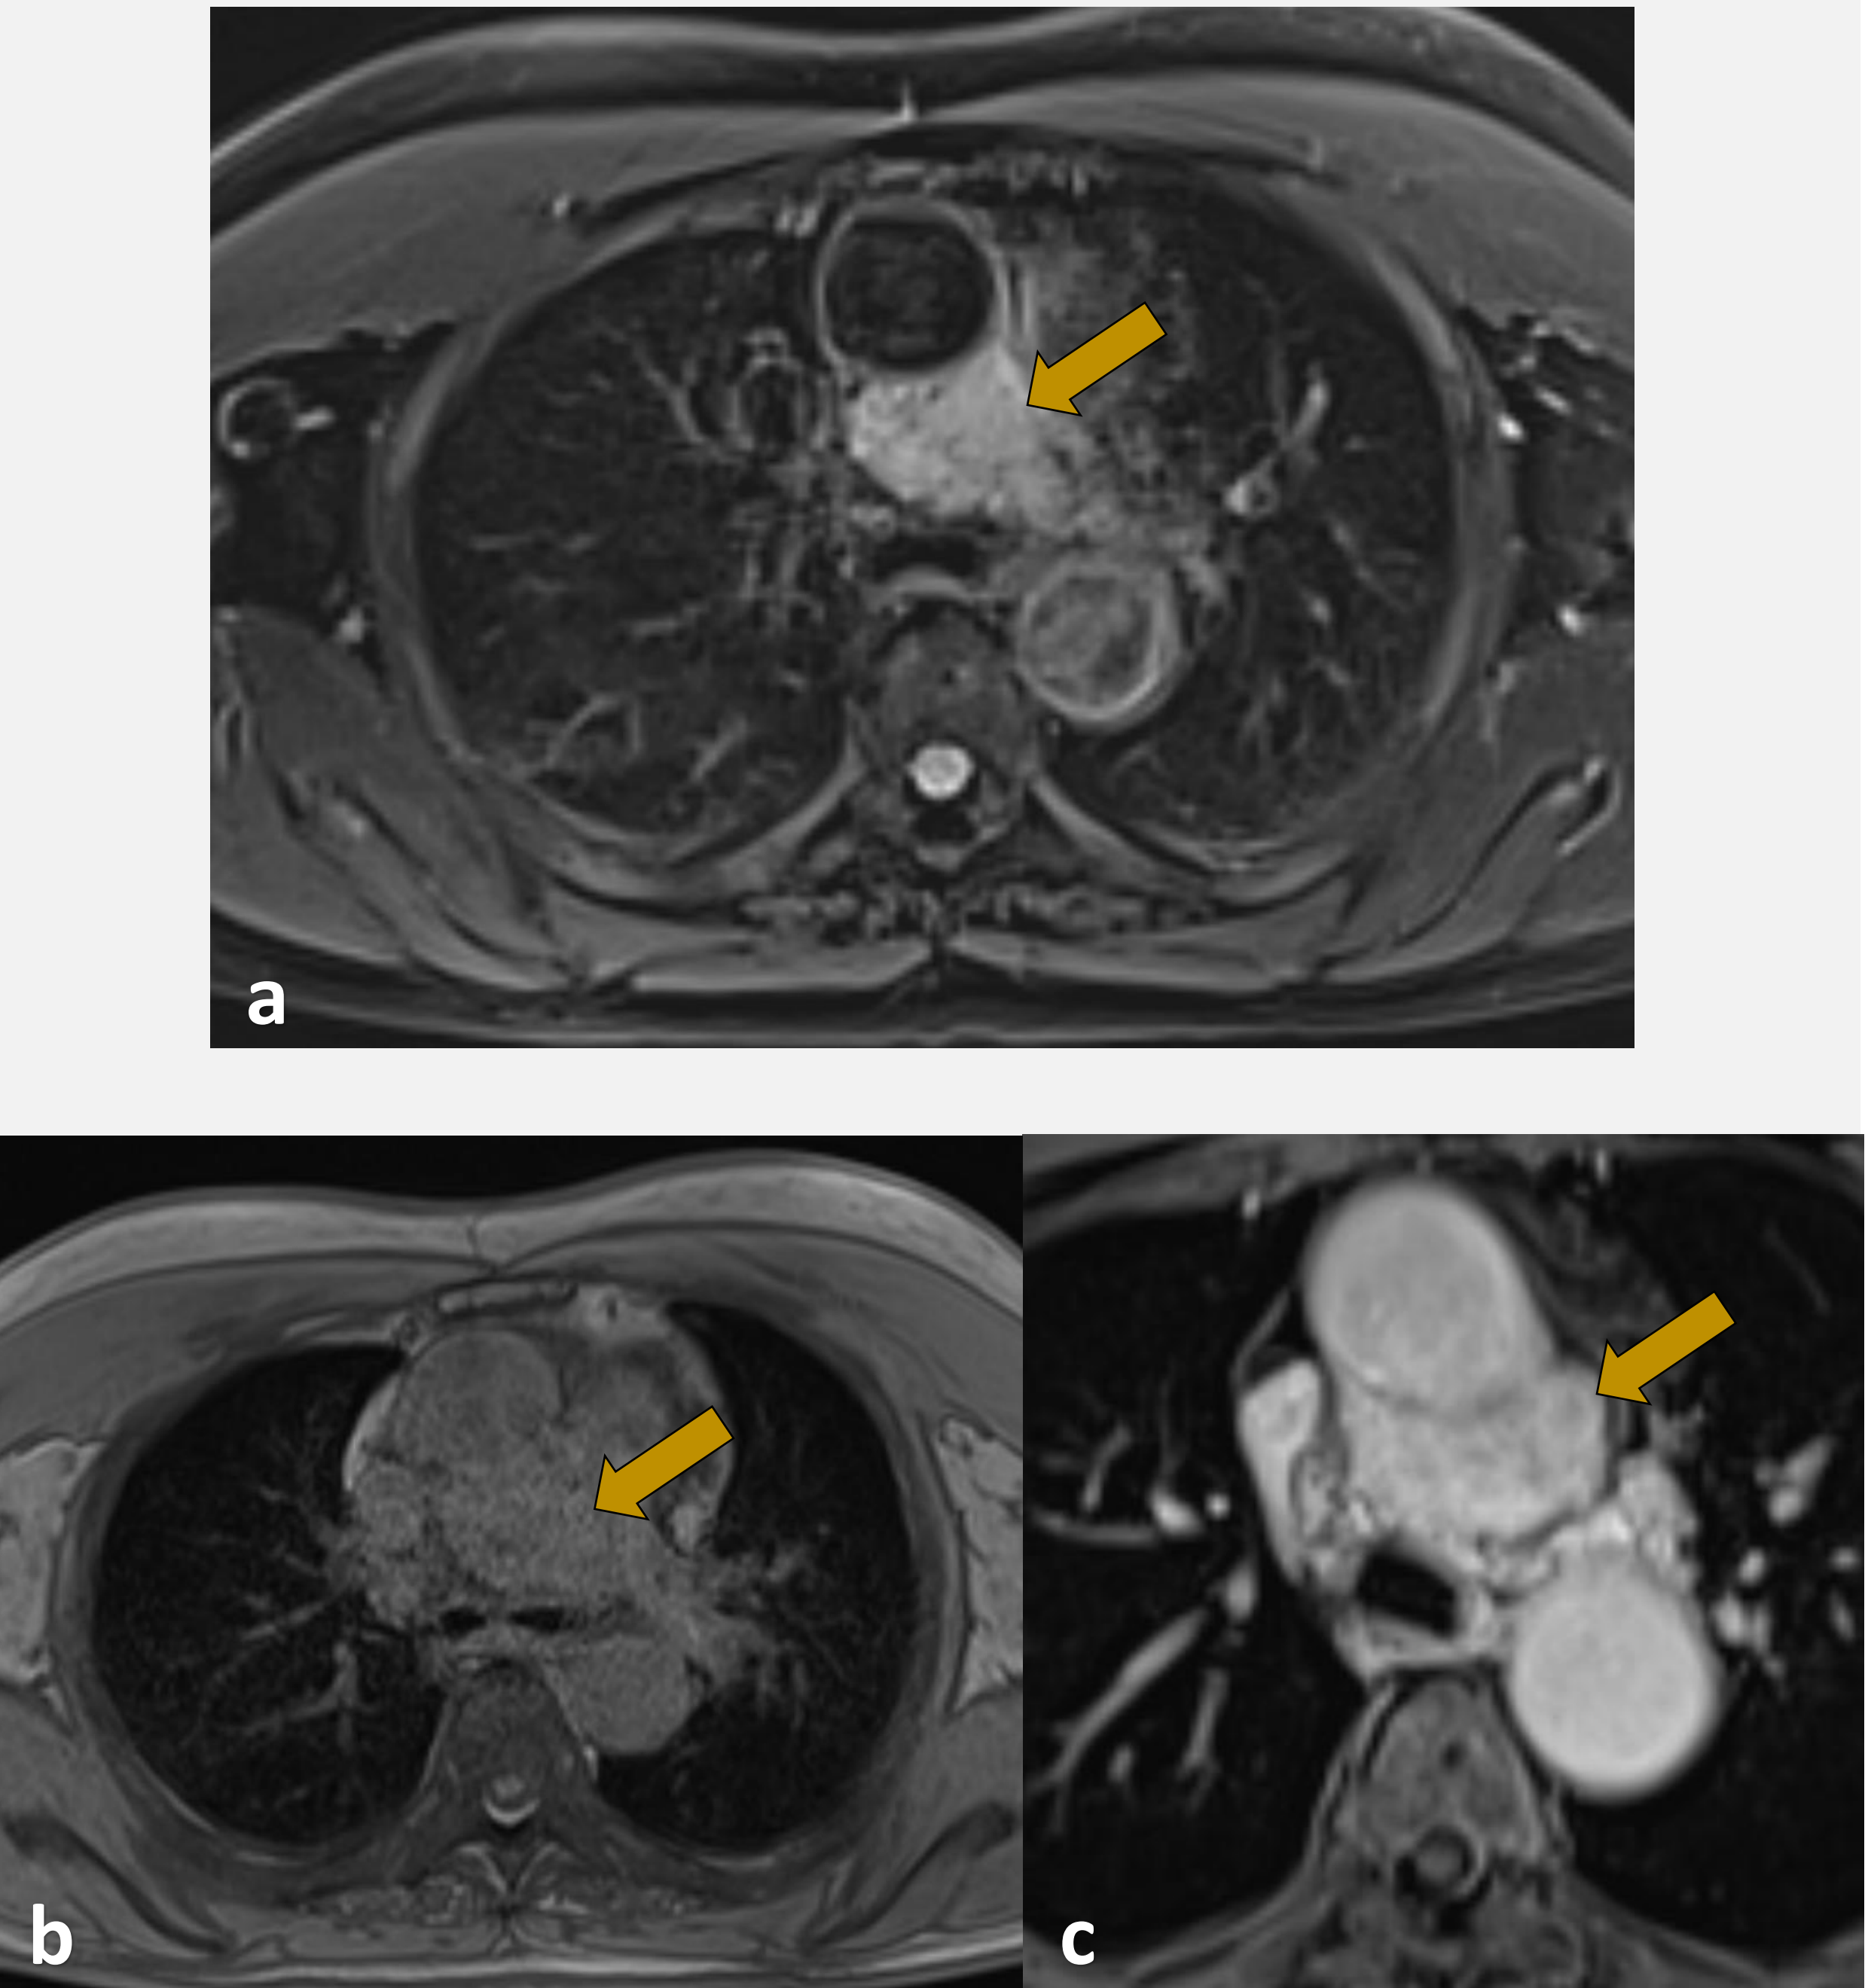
MRI findings (axial): (a) T2 fatsat, (b) T1-weighted image, (c) post-contrast T1-weighted image.
